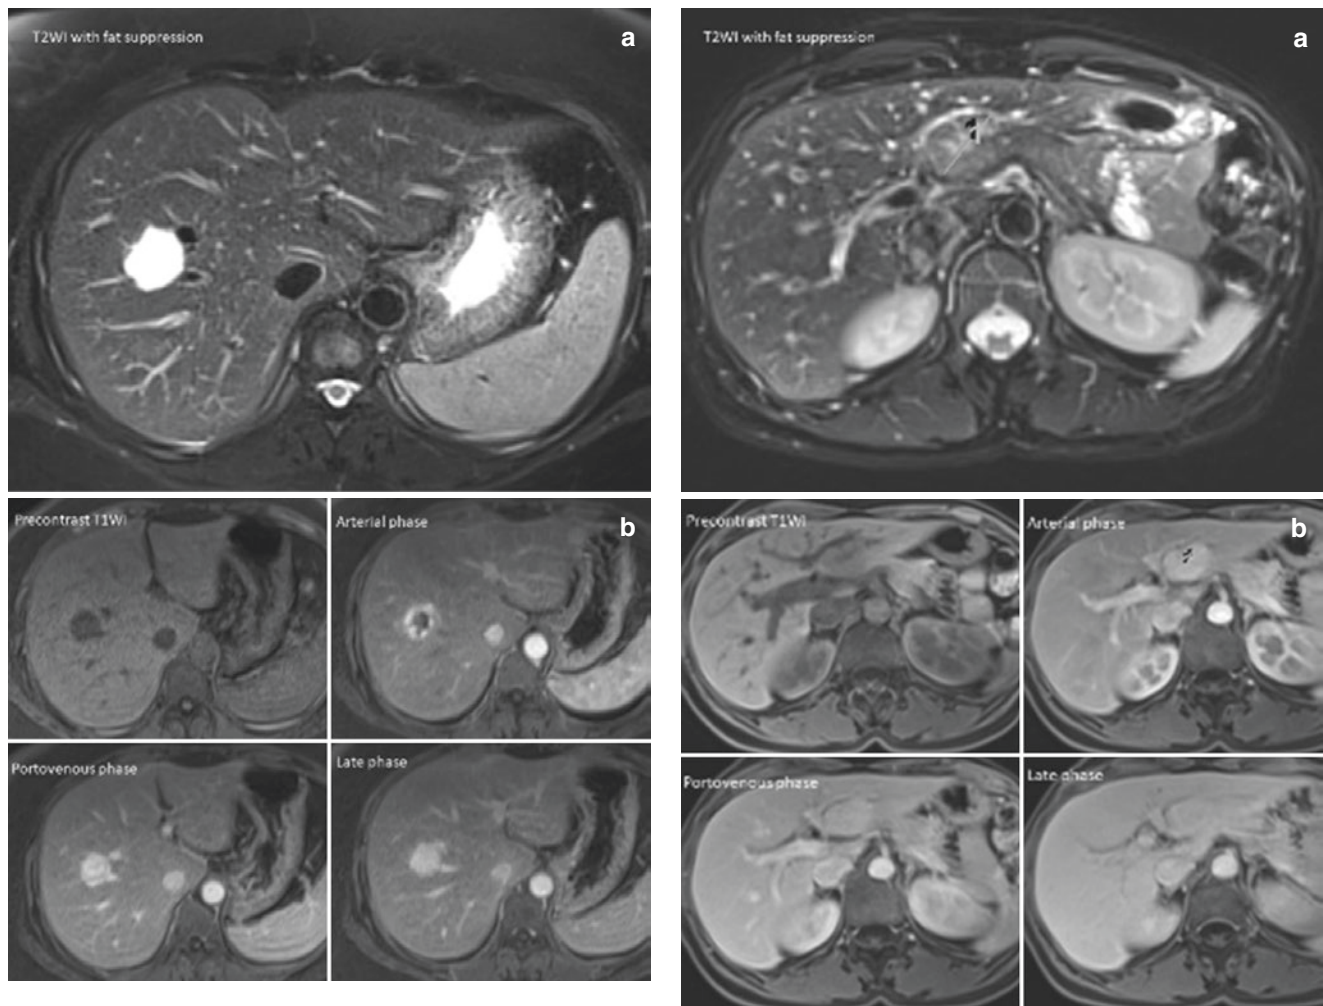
A 56-year-old female with hemangioma at S8 of liver underwent Gd-DTPA-enhanced MR imaging. (a) The tumor depicted bright signal intensity on T2W images. (b) The tumor showed hypointense on precontrast T1W imaging, peripheral nodular enhancement on arterial phase, centripetal fill-in with homogenous enhancement on portovenous/late phase images
